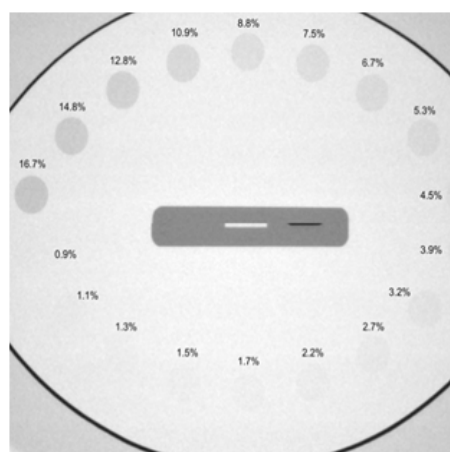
Low contrast sensitivity evaluation for the X-rays system. The structure inducing a contrast of 2% can be easily distinguished.
